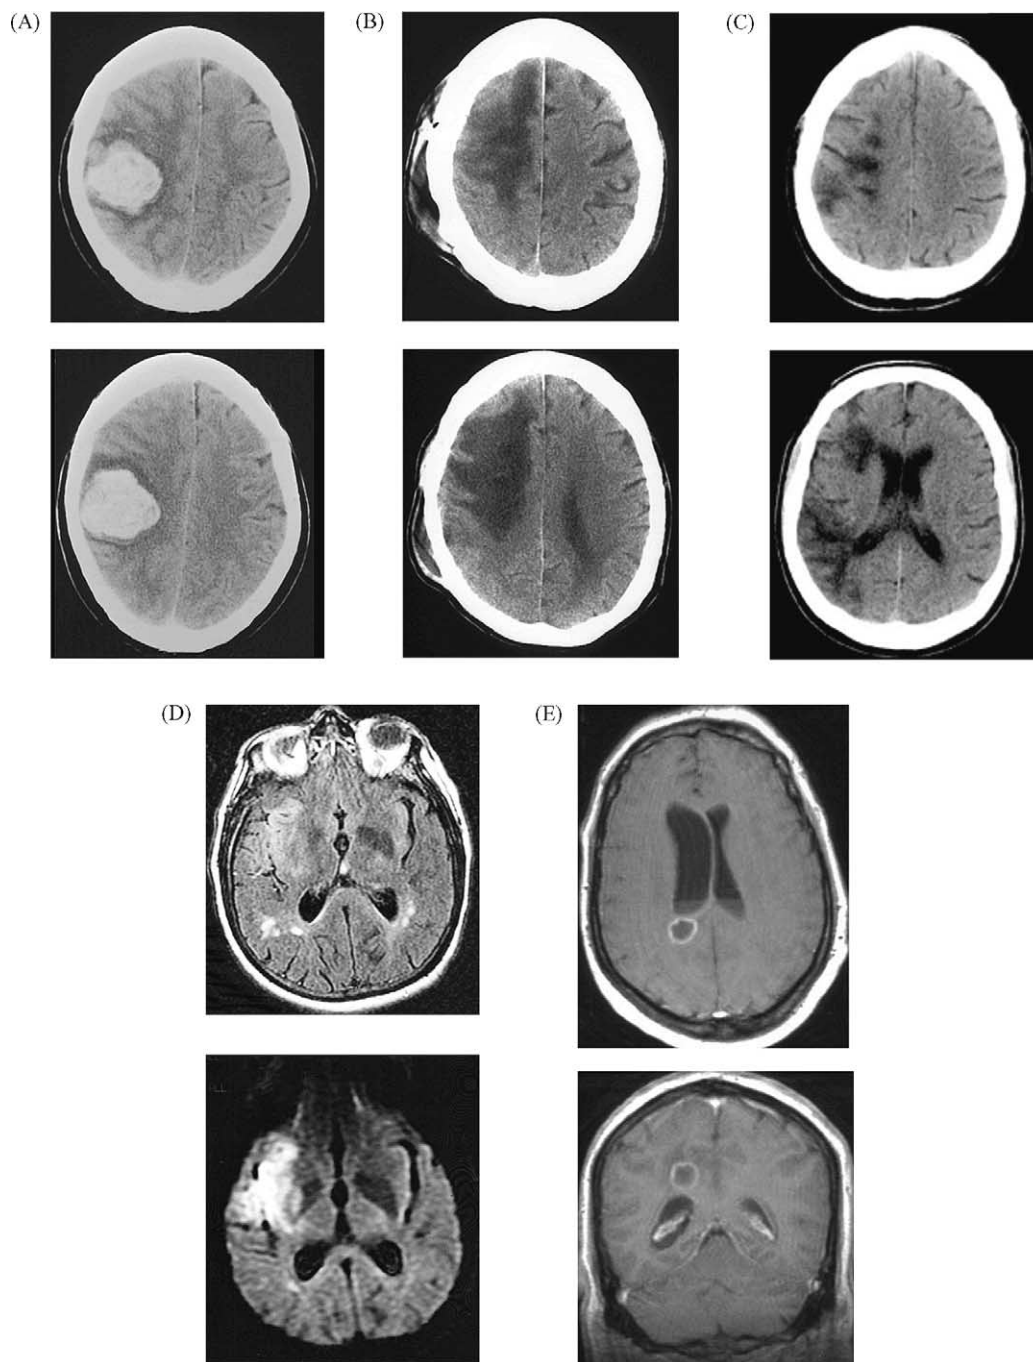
Neuroimaging data for five of the six patients with hemispatial neglect; the images were obtained by magnetic resonance imaging and computerized tomography. (A) FG; (B) FT; (C) JS; (D) MA; (E) FG. Images for patient RB were not available for publication. Following radiological convention, the right side of the brain is on the left side of the photograph.
